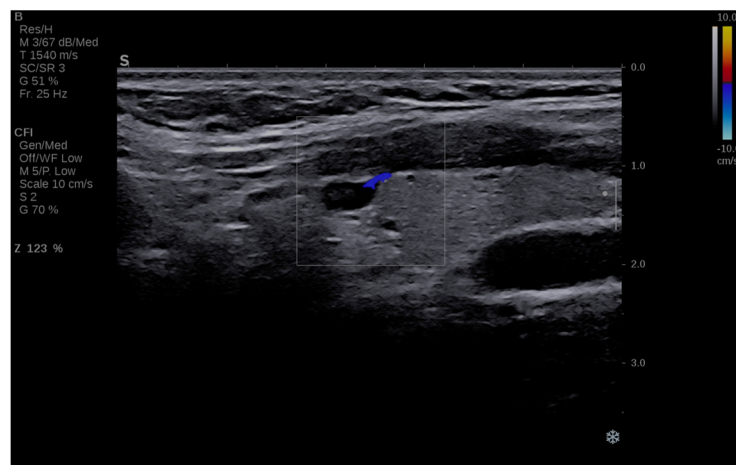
Identification of peripheral flow using Color Doppler mode, complementary to 2B mode ultrasound.
